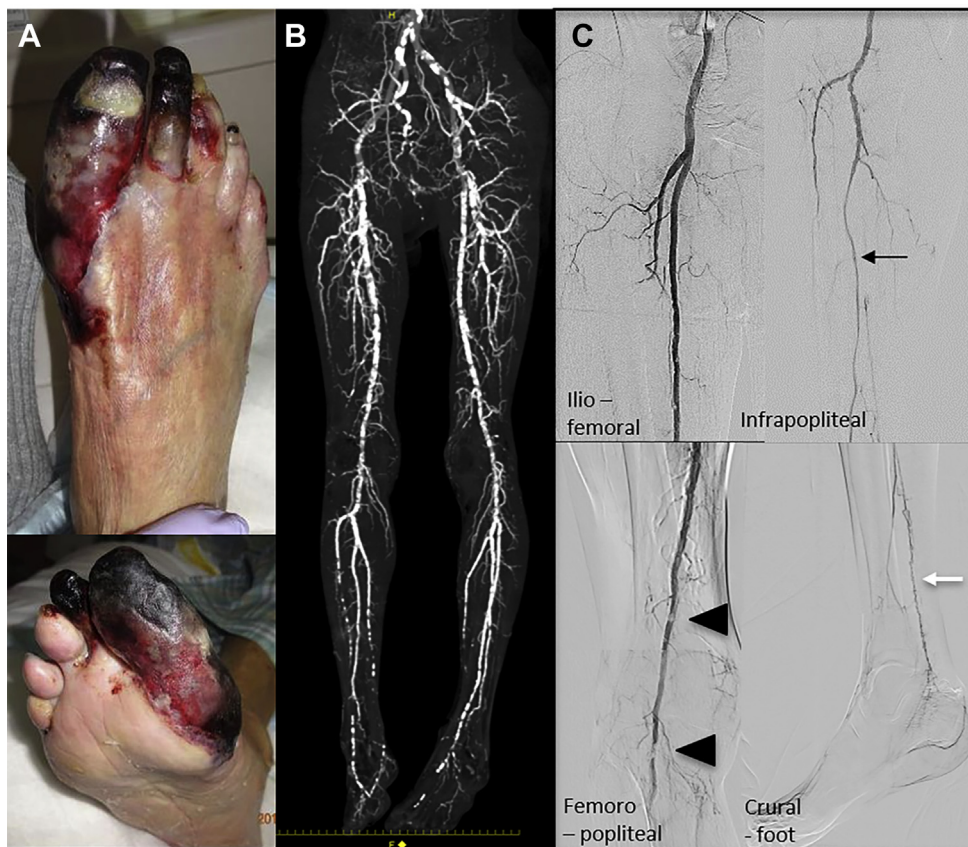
Preoperative clinical and radiographic findings. Gangrene on multiple toes of the right foot at admission (A). Computed tomography angiography demonstrates severe calcifications in lower extremity arteries (B). Intra-arterial digital subtraction angiography shows two significant stenoses of the popliteal artery (*arrowheads*), an intact peroneal artery (PA) (*black arrow*), and a developed collateral artery perfusing into the foot segment (*white arrow*). The anterior and posterior tibial arteries show chronic total occlusion (C).
